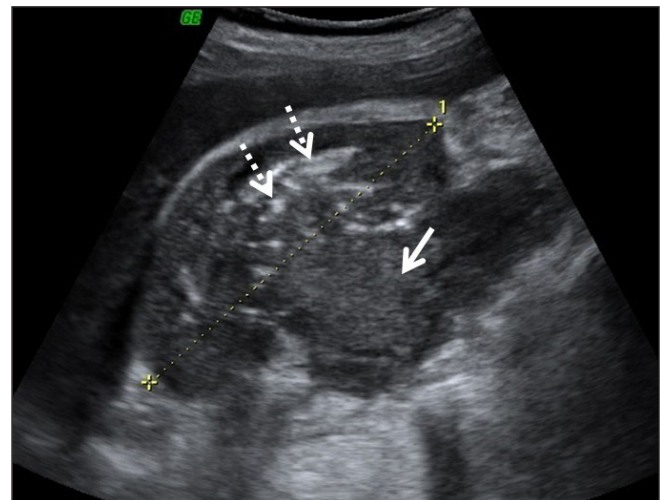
Ultrasound abdomen outlining enlarged right kidney with ill defined heterogeneous mass in postero inferior portion (arrow) containing dirty echogenic foci of air (dotted arrow).
